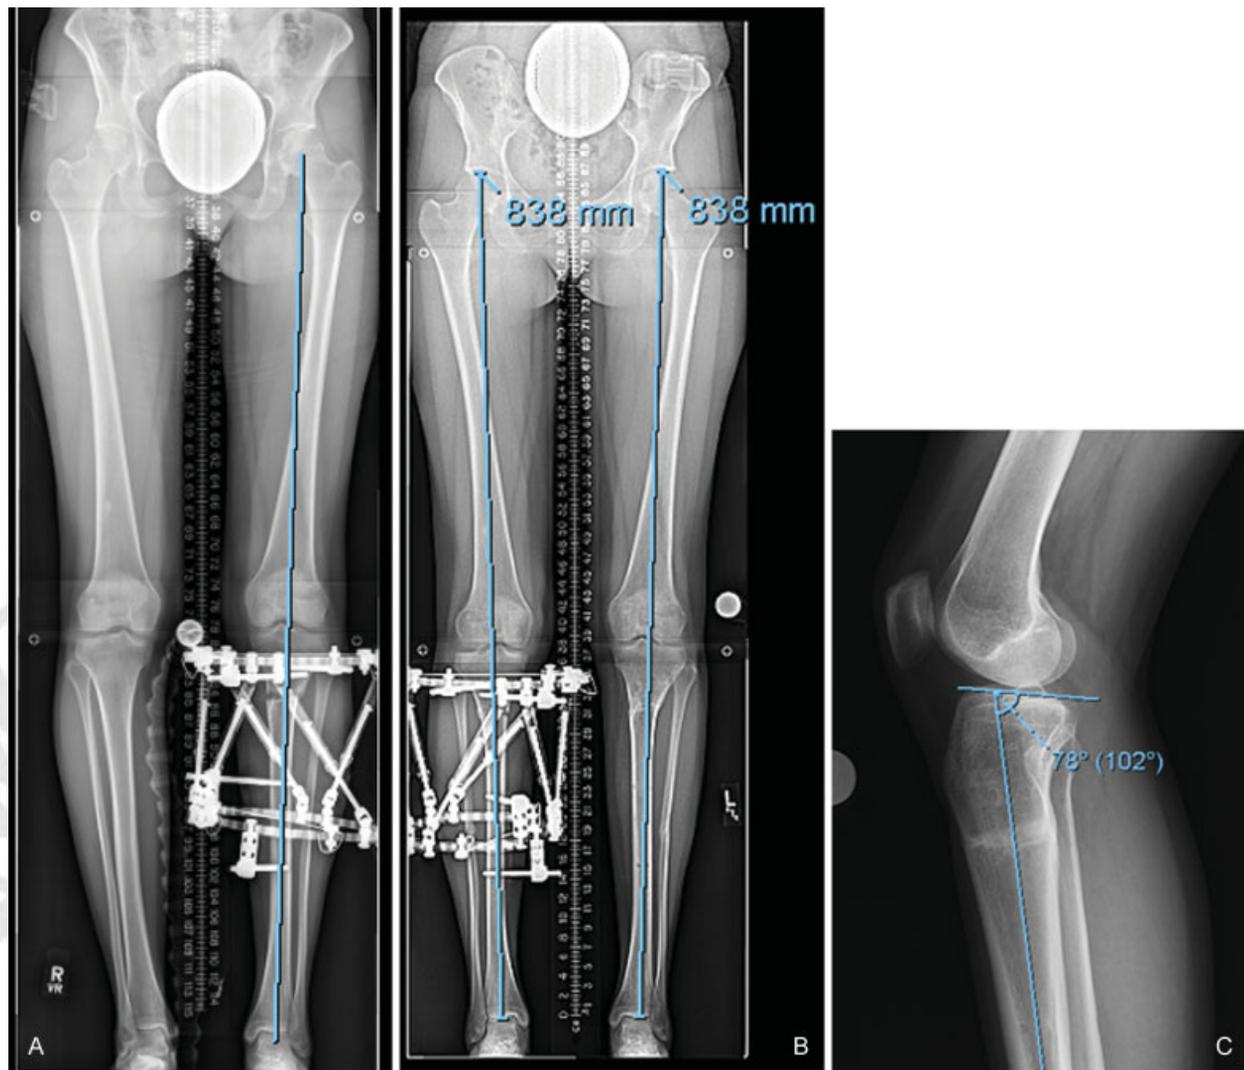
(A) Final coronal alignment is checked with a standing radiograph. The MAD is shown. (B) In the same patient seen in ► Fig. 1, the final alignment is checked and compared with the contralateral side to ensure symmetry. (C) The sagittal alignment cannot be ignored when performing a complete osteotomy and rotational correction. The adjustments could cause flexion of the proximal tibia, for example. Close attention must be paid to the lateral X-ray at the end of the adjustment period to ensure that no sagittal deformity has been introduced. In this case, the patient had full knee extension and her posterior tibial angle of 78 degrees was maintained. MAD, mechanical axis deviation.
